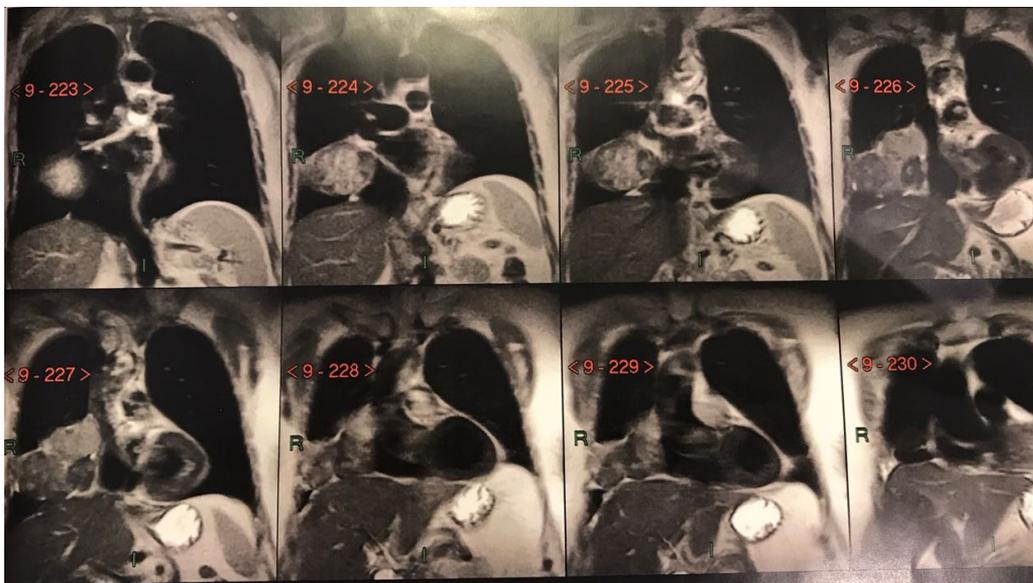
Coronal chest MRI
